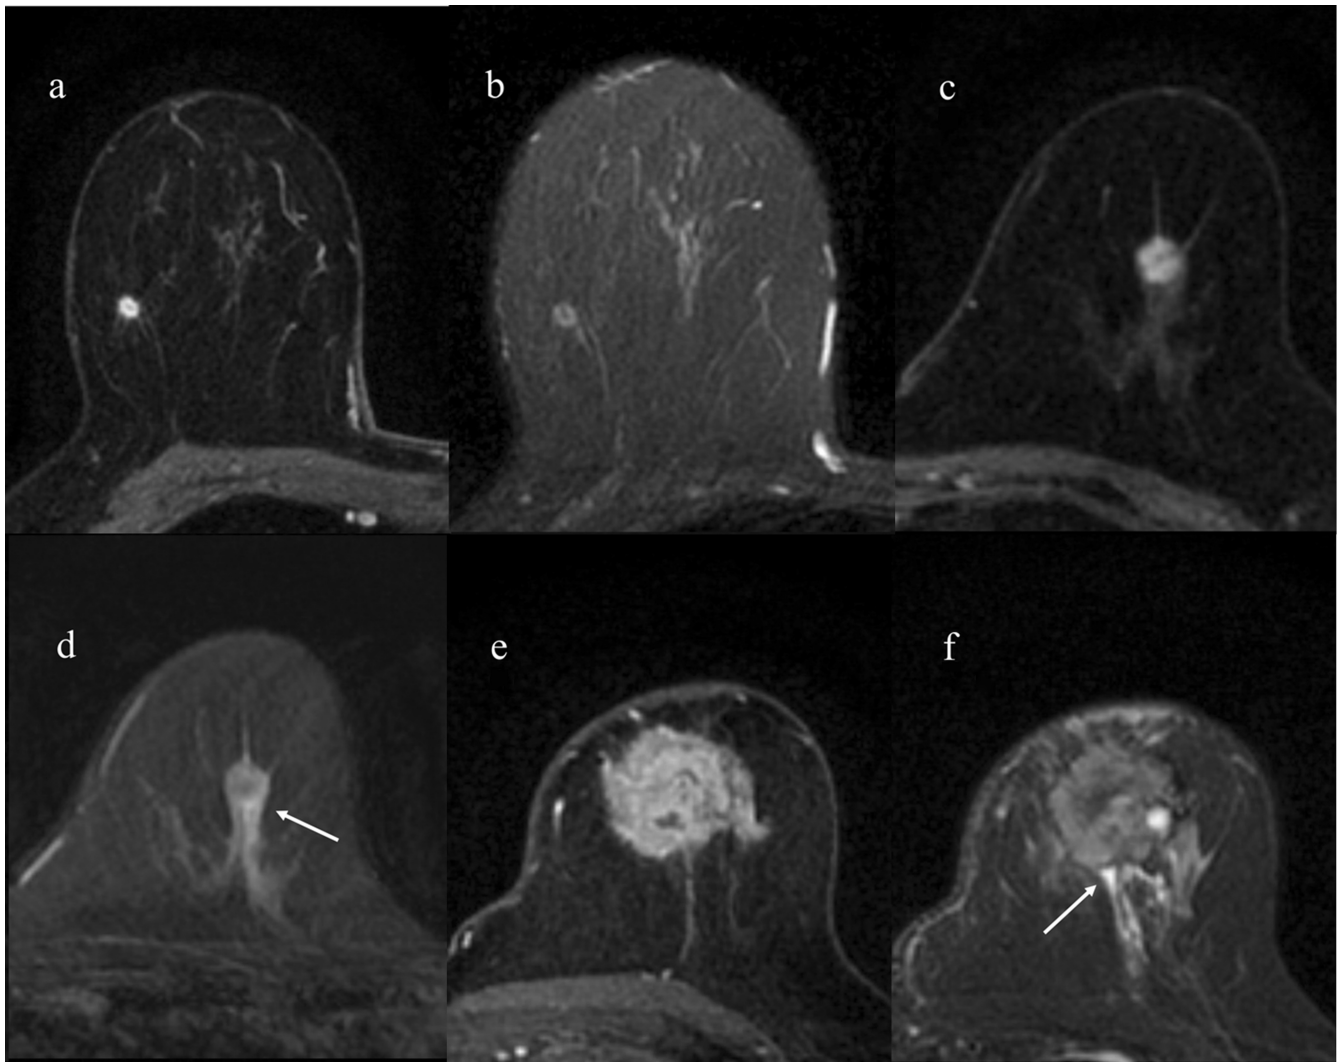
Peritumoral edema surrounding the tumor on T2-weighted MR images. (a and b) Grade 0: axial fat-suppressed post-contrast T1-weighted (a) and T2-weighted (b) images indicate an absence of high signal intensity. (c and d) Grade 1: axial fat-suppressed post-contrast T1-weighted (c) and T2-weighted (d) images indicate that the signal intensity surrounding the tumor is moderately high but is less than that of water (arrow in d). (e and f) Grade 2: axial fat-suppressed post-contrast T1-weighted (e) and T2-weighted (f) images indicate that the signal intensity surrounding the tumor is as high as that of water (arrow in f).
